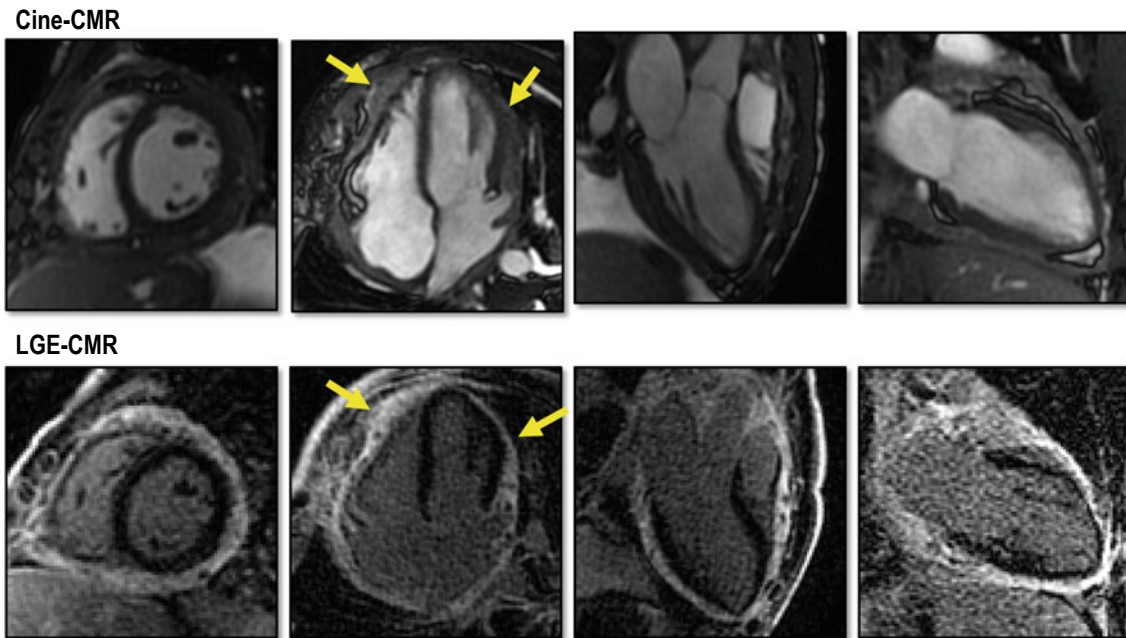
Cardiac MRI in short-axis and long-axis views showing metastatic angiosarcoma presenting as thickened pericardium adherent to the left and right ventricles (arrows) on still images of cine-CMR
